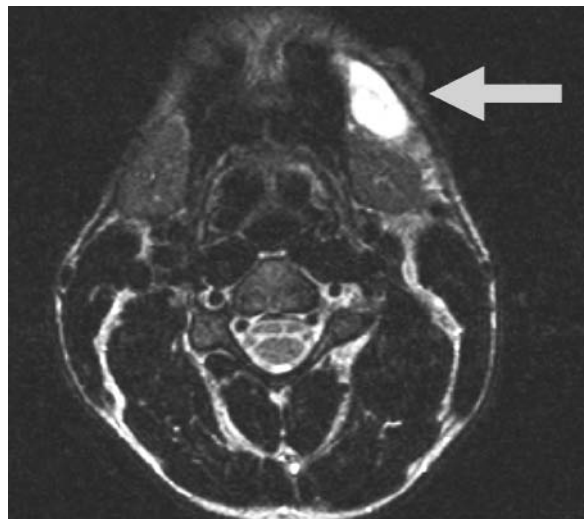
Axial T2-weighted MRI of plunging ranula
